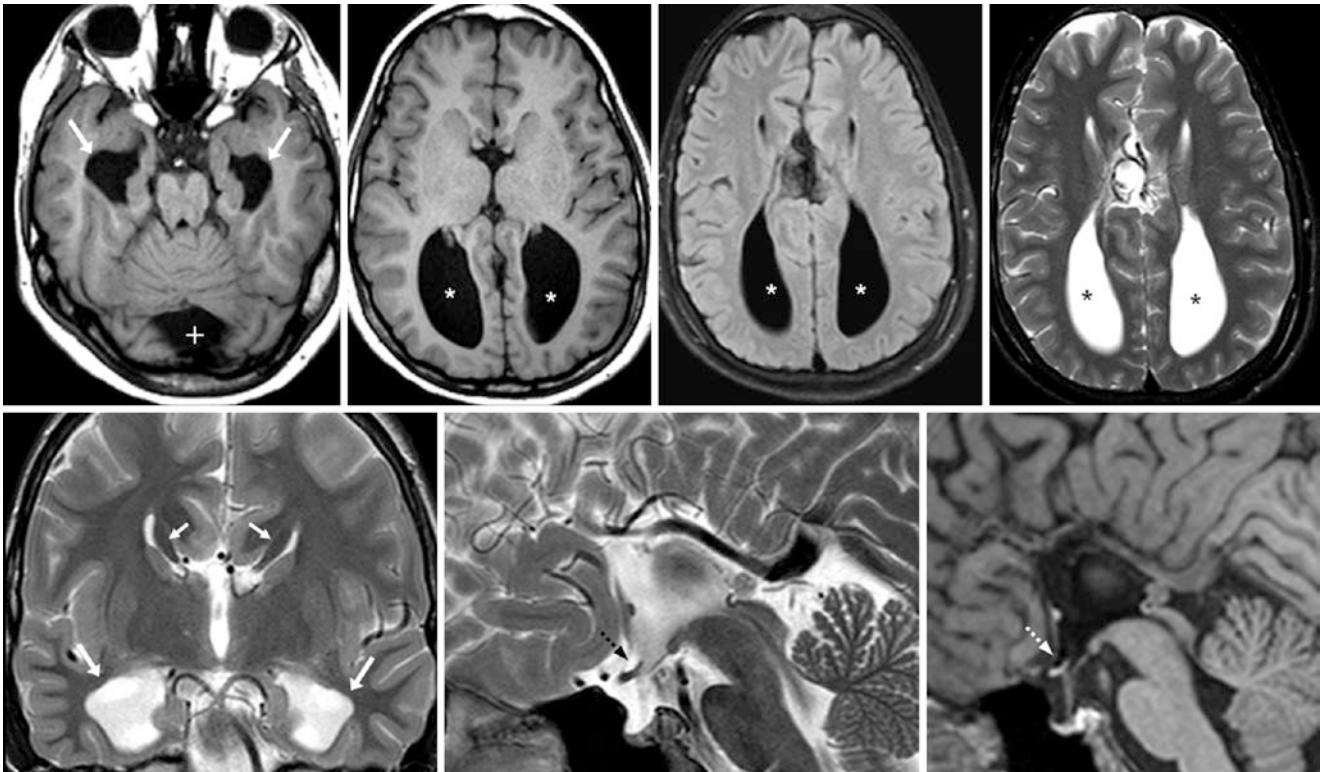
Comparison case of colpocephaly from callosal agenesis. A 12 year old had enlarged posterior bodies (*) and temporal horns (arrows) of the lateral ventricles that mimic hydrocephalus on T1WI (top left and left middle), FLAIR (top, right middle), and T2WI (top right). Callosal
